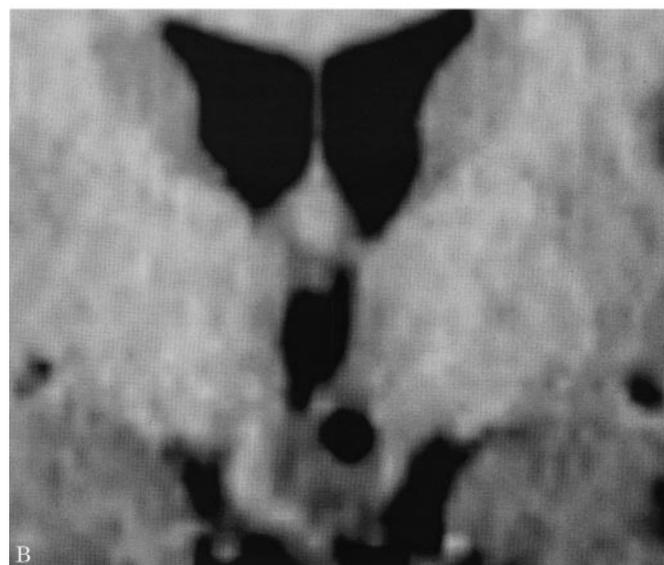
Intrahypothalamic hamartoma as seen on sagittal and coronal T1-weighted MR slices. A, B) Midsagittal and coronal T1-weighted MRI sections 3 months after intrahypothalamic implantation of a ^{125}I seed (the biopsy site is indicated by a hypointense titanium ball, diameter: 0.5 mm). (Courtesy of Prof. Schumacher, Dept. Neuroradiology, University Clinic of Freiburg.)
